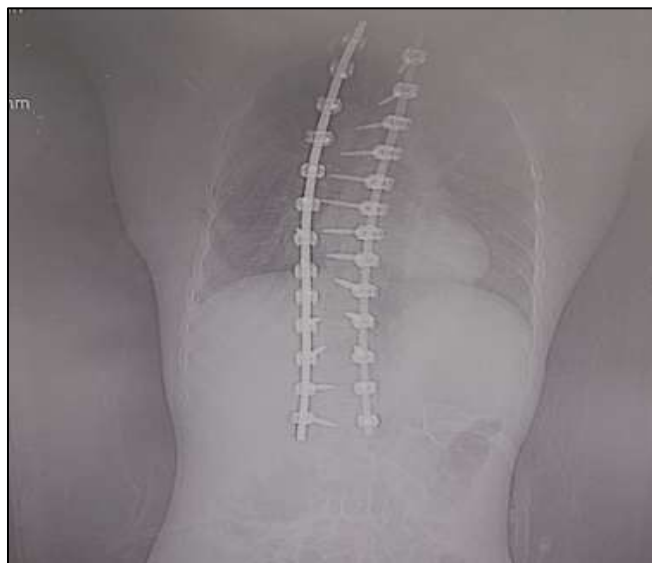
Post-operative X-ray and fused spine with hook and screw construct.
